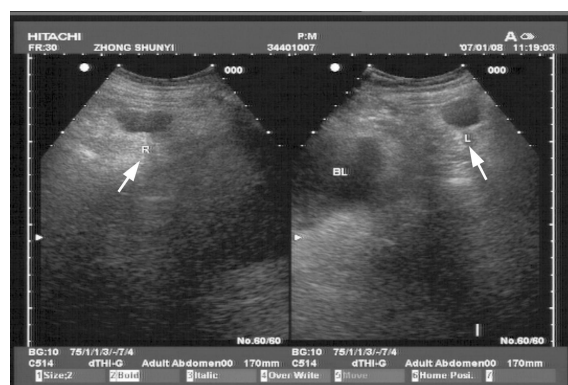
The ultrasonography of the lymphocysts after operation
